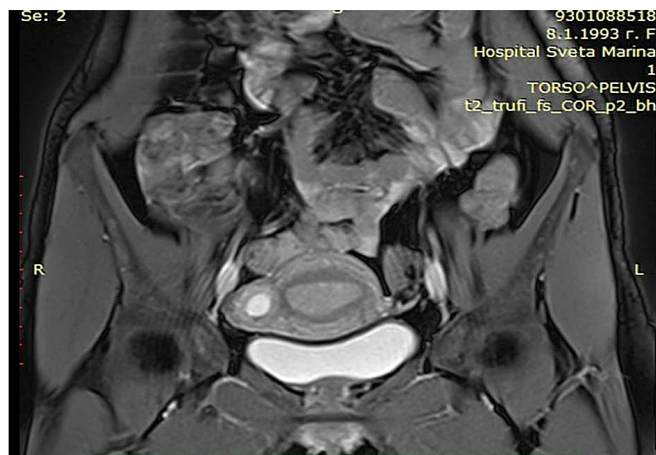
MRI picture of the pelvis. In the area of the right uterine horn in the tunica muscularis, an oval area, suggestive of a gestational sac, with a diameter of 20 mm.
